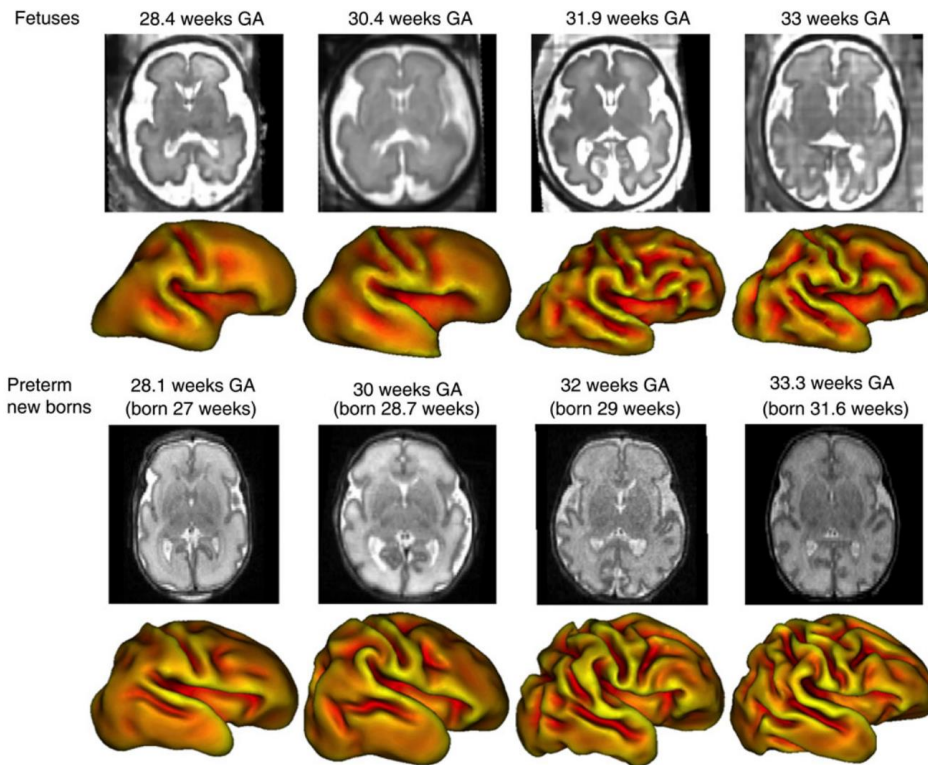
Representation of axial MRI slice and corresponding volumetric reconstructions of cortical meshes at multiple ages in the fetus (Top rows) and in the preterm (bottom rows) (courtesy of Lefèvre et al., 2016)
